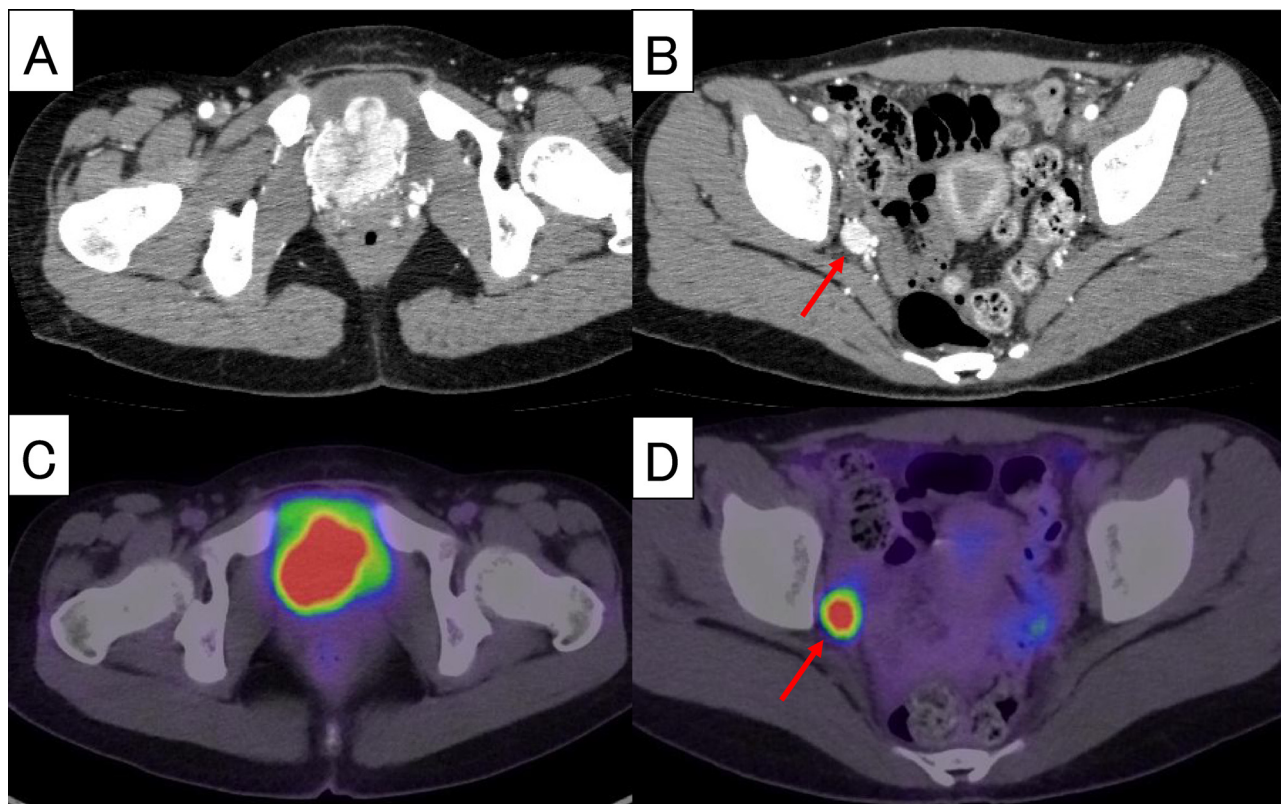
CT and FDG-PET/CT images of the pelvic paraganglioma and lymph node metastasis of the patient, a 17-year-old female. Axial CT images showed a hypervascular well-defined and lobulated mass (55 mm in long dia.) located dorsocaudal to the urinary bladder (A) and enhanced lymph node swelling (15 mm in short dia.) at the right internal obturator region (B, red arrow). C,D: Intensely high FDG accumulation in the tumor and the lymph node with SUVmax values of 24.7 and 20.8, respectively.
